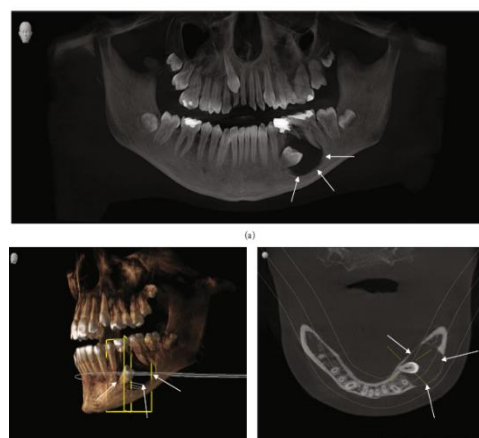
(a) OPG X-ray showing unilocular radiolucency in the left premolar region of the mandible. (b) 3D CBCT showing cystic lesion and its relation to other anatomical structures of the mandible. (c) CBCT showing coronal view of the cystic cavity.
